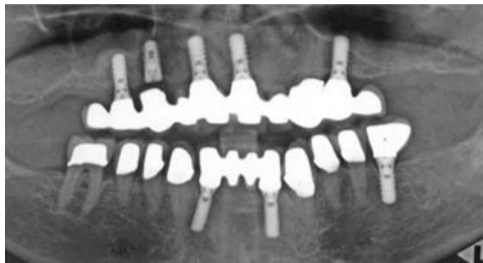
Panoramic radiograph obtained after implant insertion at position #6.
